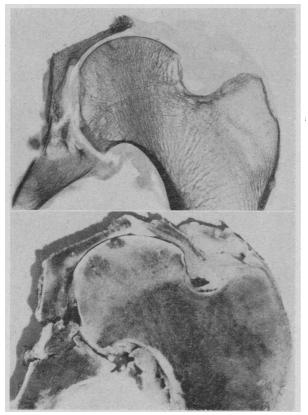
Hip in coronal section showing isolated erosion of femoral head, synovial proliferation, and acetabular erosion. X-ray of slice above, gross photograph below.
